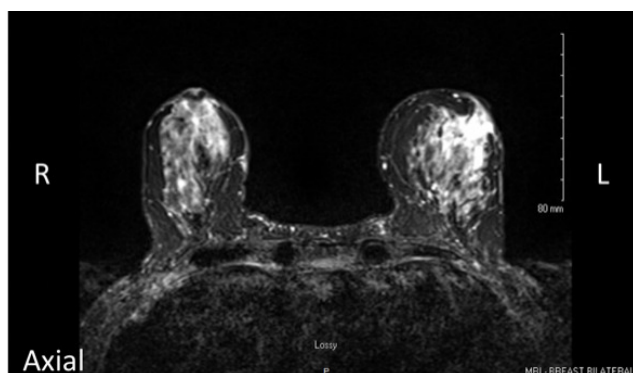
Bilateral Breast Magnetic Resonance Imaging.
